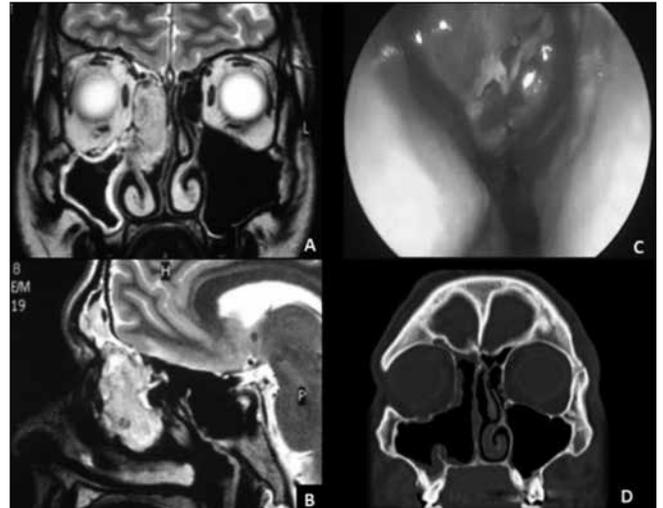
Coronal and sagittal T2-weighted images. Pre-operative MRI shows a large, well-defined mass expanding the right ethmoid. The mass lesion exhibits intermediate signal on T2-weighted images, due to its high cellularity; there is no evidence of infiltration of the orbital fat and of the fovea ethmoidalis. Inflammatory/obstructive changes are seen in both right frontal and maxillary sinuses due to mass effect on the ostio-meatal unit. Right lamina papyracea was compressed by the mass, but not interrupted; the orbit, anterior cranial fossa and brain were disease-free. C. Endoscopic view of the right nasal fossa: a fairly well circumscribed, multi-lobulated smooth rounded mass, involving the right ethmoid sinus and the region of middle turbinate is showed. Bony destruction was not recognisable, but the mass effect was prominent. D. Post-operative coronal CT image demonstrates the ethmoido-maxillectomy, without evidence of residual/recurrent disease.
